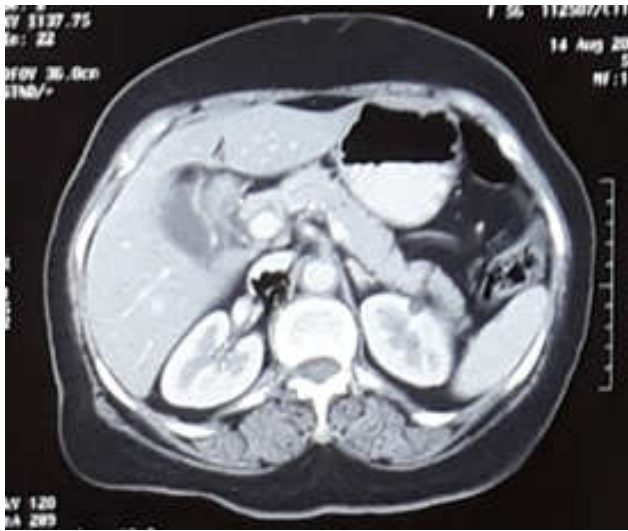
CT scan abdomen showing GB Mass (Before radical cholecystectomy)
